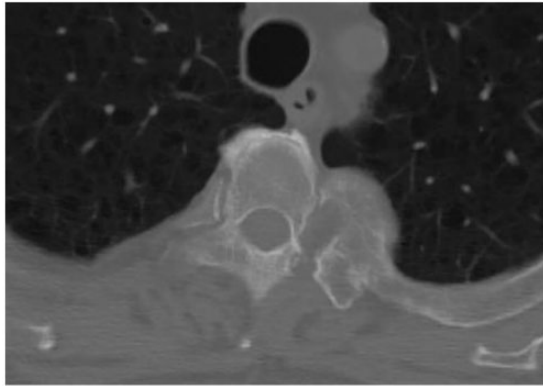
CT image of the fourth left rib one year after the biopsy. The tumor showed calcification, but had not enlarged since the biopsy.
